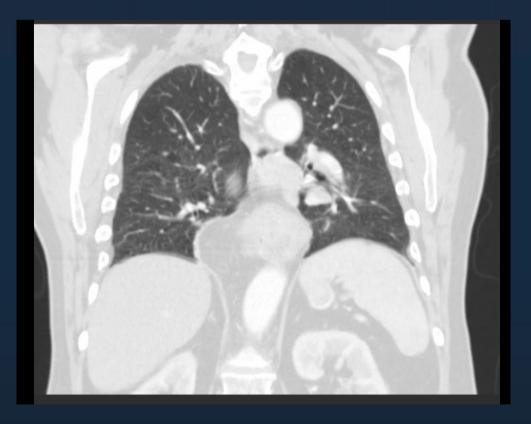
CT Thorax with IV Contrast Visualizing a Lingula Mass.
